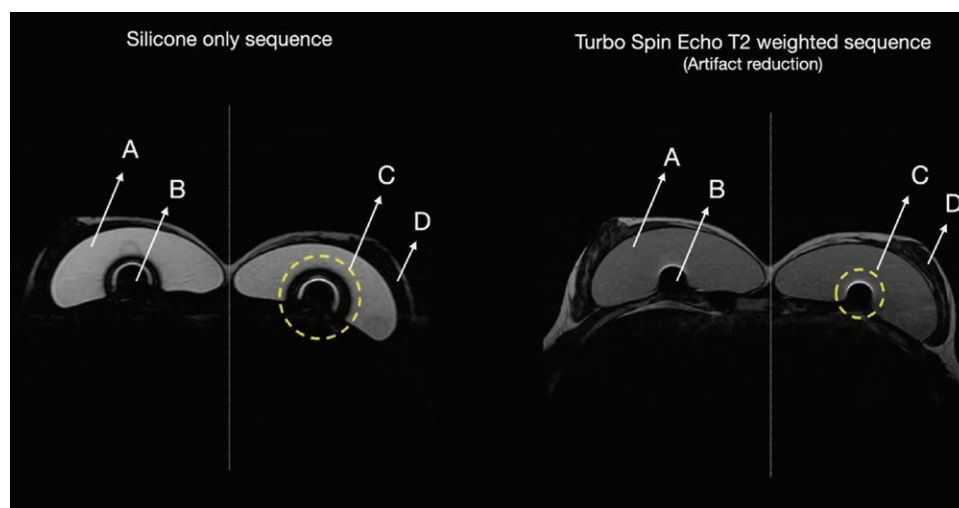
Comparison of a silicone only (left) and a turbo spin-echo T2-weighted sequence (right), showing substantial artifact reduction. A, silicone gel implant; B, RFID microchip; C, area of the RFID artifact; and D, breast tissue.
